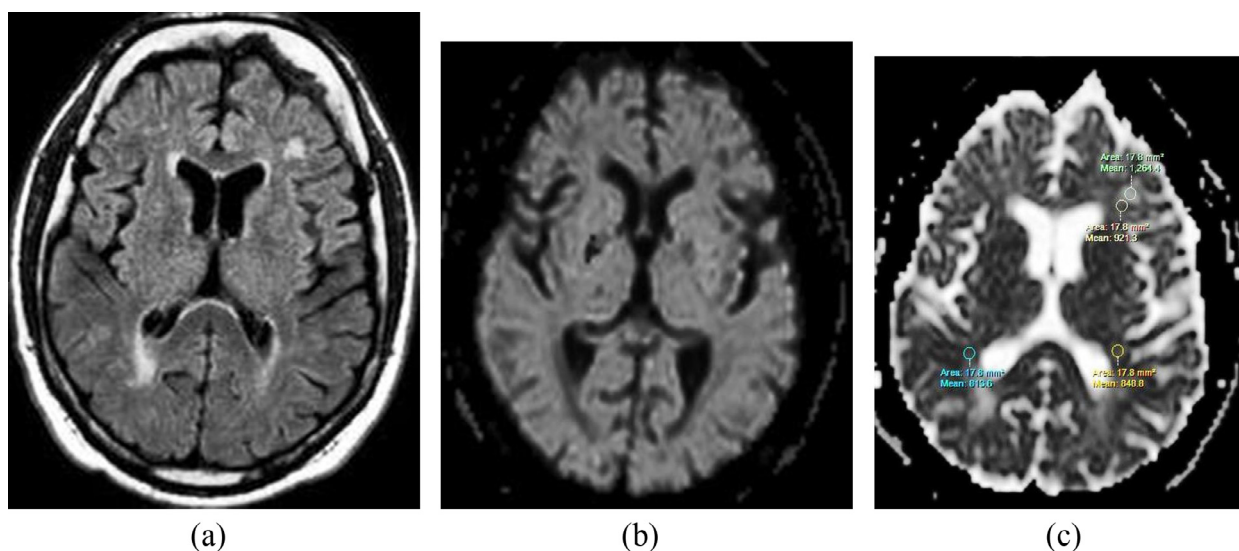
39 year old male patient with RRMS and mild cognitive impairment (MOCA score 19). (a) Axial FLAIR showed multiple plaques, (b) DWI image showed signal intensity of facilitated diffusion, (c) ADC map showed the following readings: Plaque 1.2644×10^{-3} , Peri-plaque 0.9213×10^{-3} , and NAWM $0.8488 \times 10^{-3} \text{ mm}^2/\text{s}$.
